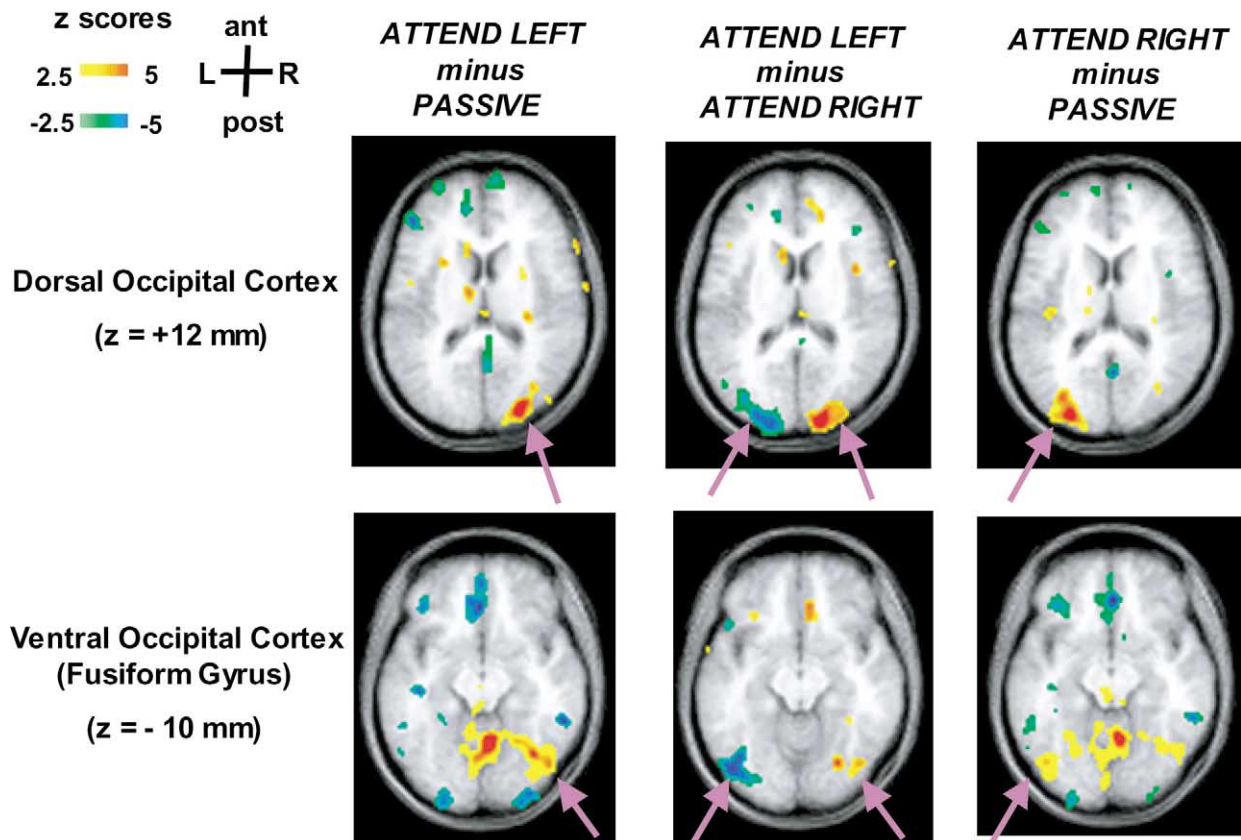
Grand-averaged z-score PET difference images (axial) showing the effects of lateralized visual attention at two levels of occipital cortex: dorsal (Talairach  $z = +12$ ) and ventral (Talairach  $z = -10$ ; fusiform gyrus). The PET activity maps are shown overlaid on the grand-averaged structural MRI images from the same subjects. As with the ERPs in Fig. 2, the contrasts shown are for attend-left vs. passive, attend-right vs. passive, and attend-left vs. attend-right. Note the particularly strong activity in the *contralateral dorsal occipital areas* (Brodmann Areas (BA) 18/19) (top) with some, but lesser, activation in ventral occipital cortex (bottom).
